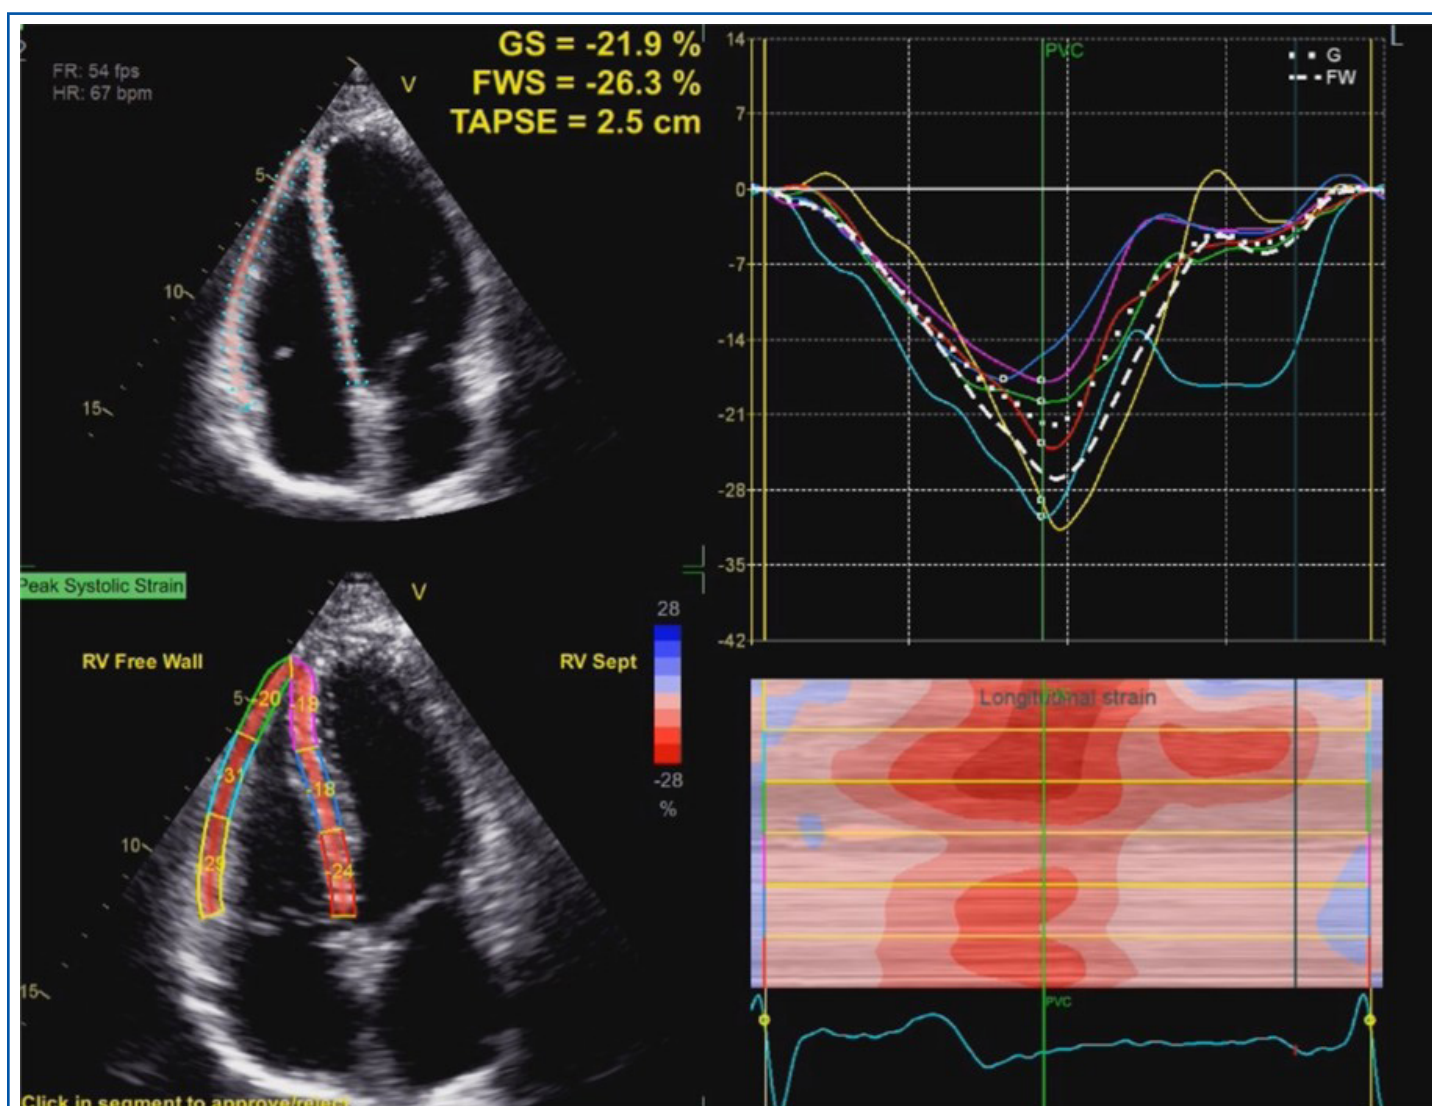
Transthoracic 2D speckle tracking echocardiography showing normal RV strain in patient's daughter with DSP variant. 2D, two-dimensional; DSP, desmoplakin; RV, right ventricular.
